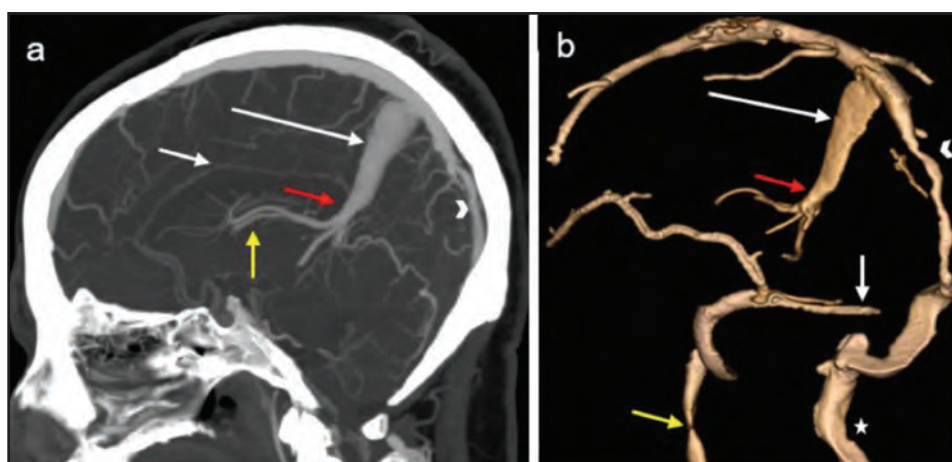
A 56-year-old woman with a history of Hashimoto’s thyroiditis presented with a chronic headache for a few months. Sagittal CT cerebral venogram image (a) reveals a persistent falcine sinus (long arrow) connecting the vein of Galen (red arrow) to the superior sagittal sinus. The paired internal cerebral veins (yellow arrow) fused to form the vein of Galen (red arrow). The inferior sagittal sinus (short white arrow) drains posteriorly into the persistent falcine sinus (long white arrow). The posterior third of the superior sagittal sinus is rudimentary (arrowhead). Three-dimensional volume rendering technique (VRT) CT venogram rotated image (b) shows the persistent falcine sinus (long arrow) connecting the vein of Galen (red arrow) to the superior sagittal sinus. There is a rudimentary posterior third of the superior sagittal sinus (arrowhead), and the right transverse sinus is hypoplastic (short white arrow). There is a small calibre right internal jugular vein (IJV) (yellow arrow). As the straight sinus is absent in this case, the venous drainage is preferentially through the persistent falcine sinus (long white arrow) and the left transverse and sigmoid sinus into the left IJV (star)
